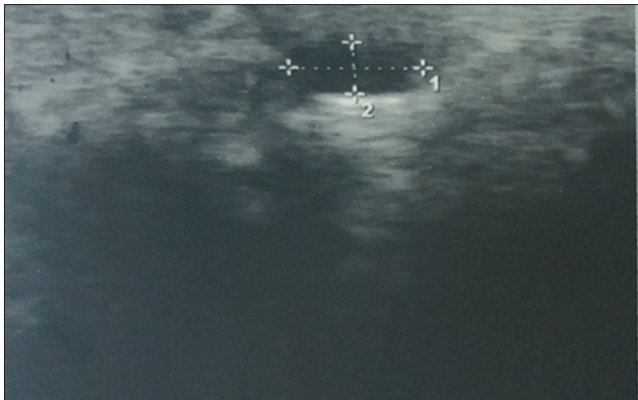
Ultrasound of the finger showing a hypoechoic oval, well limited nodule
